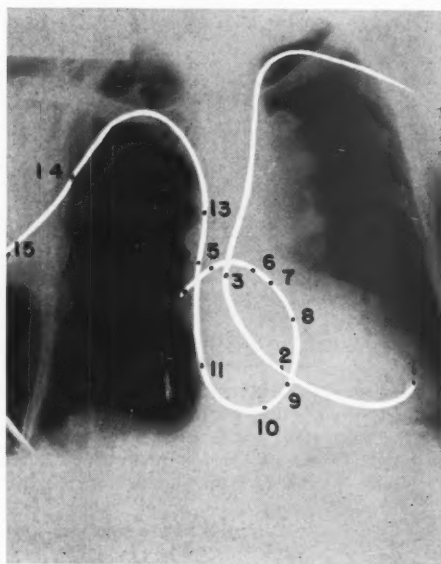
Roentgenogram of patient, C. S., showing indwelling cardiac catheters with their tips in the right pulmonary artery and in the apex of the left ventricle. The numbers refer to positions of the tip of the catheters at which records in the following figures were obtained.
